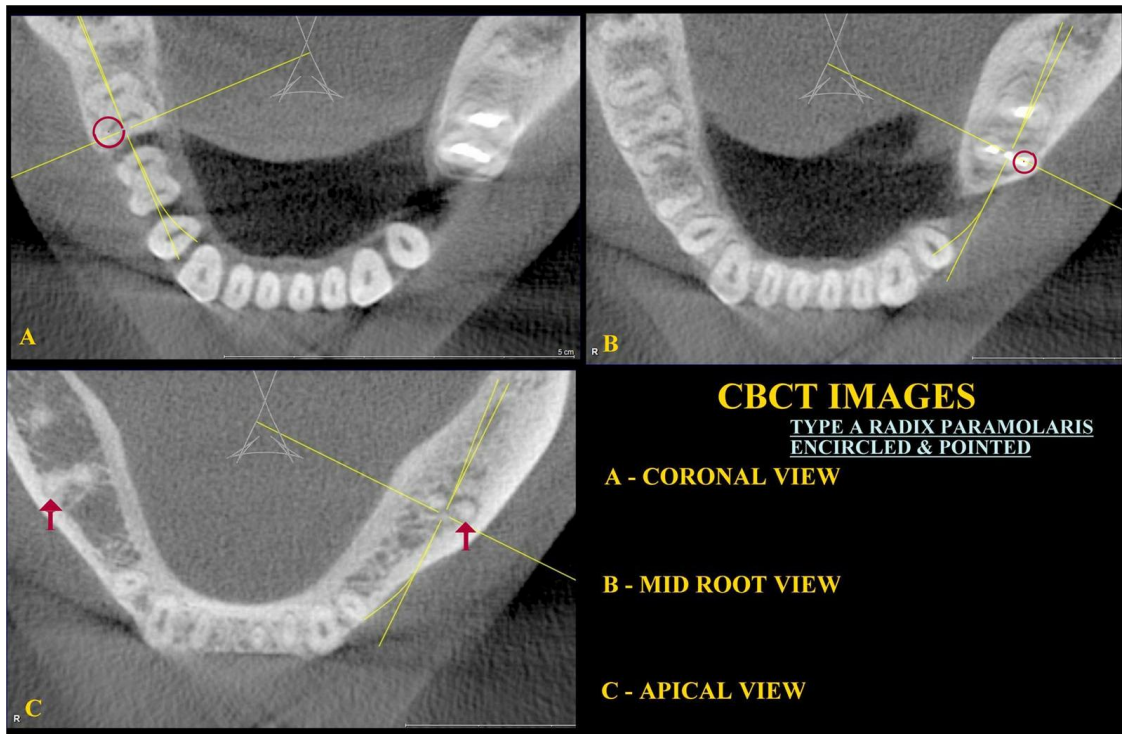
CBCT; arial view in sections
